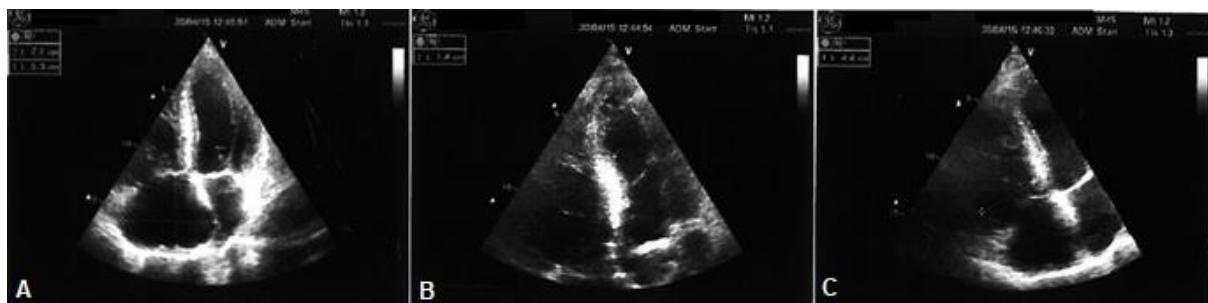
Trans-thoracic-echocardiography in PAH patients
